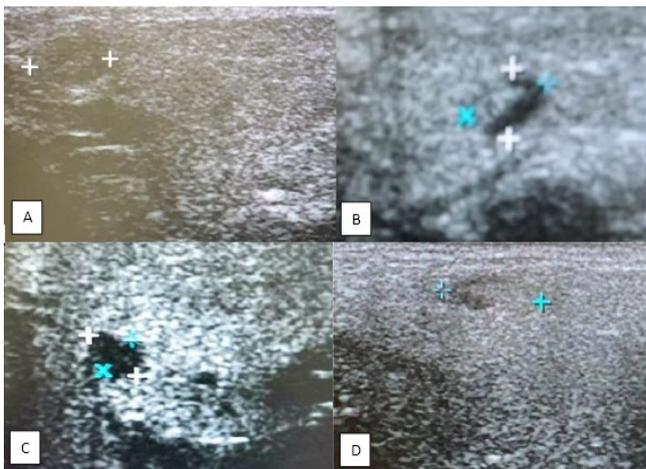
Various sonographic changes in the parotid gland. 1A. Fatty infiltration. 1B. Lymphadenopathy. 1C. Lymphoepithelial cyst. 1D. Hypoechoic areas.
